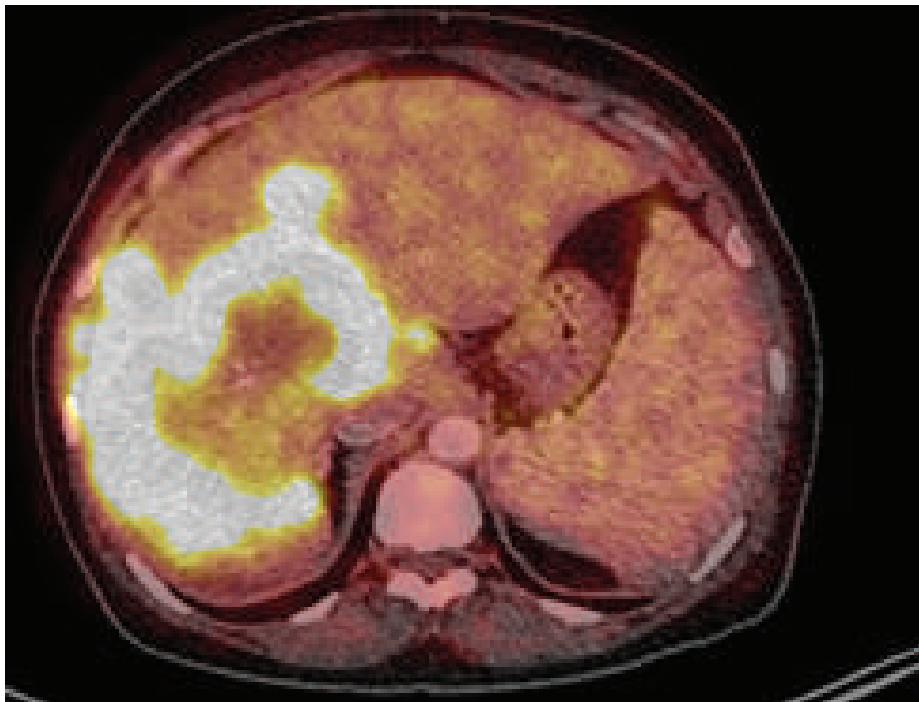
PET-CT image of a 57 years old woman with left breast carcinoma patient shows, huge FDG avid (SUV max :12.5) rim enhancing, necrotic, intra hepatic, hyper vascular mass (measuring about CC- 9.9, TD- 9.8 & AP- 10.9 cm), compression over right branch of portal vein, involving segment V, VI, VII & VIII; possibly metastases.
